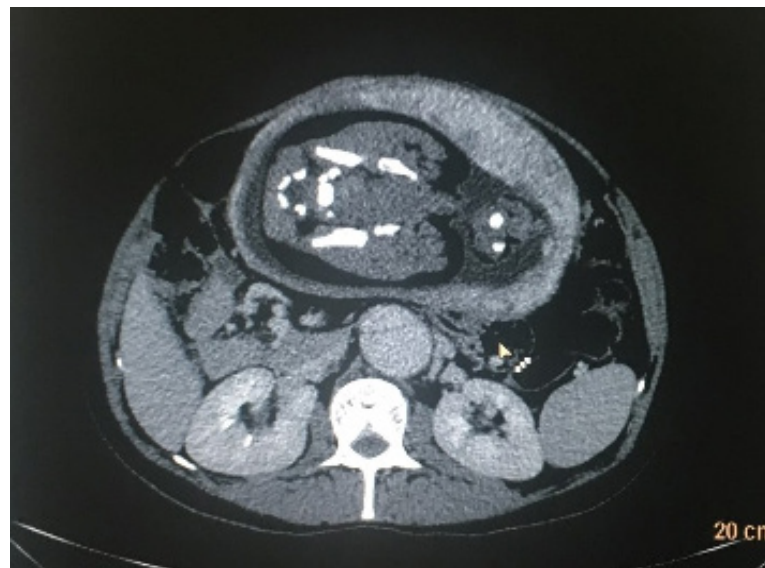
Computed tomography in axial view showing the dissection extending to the origin of the renal arteries.
